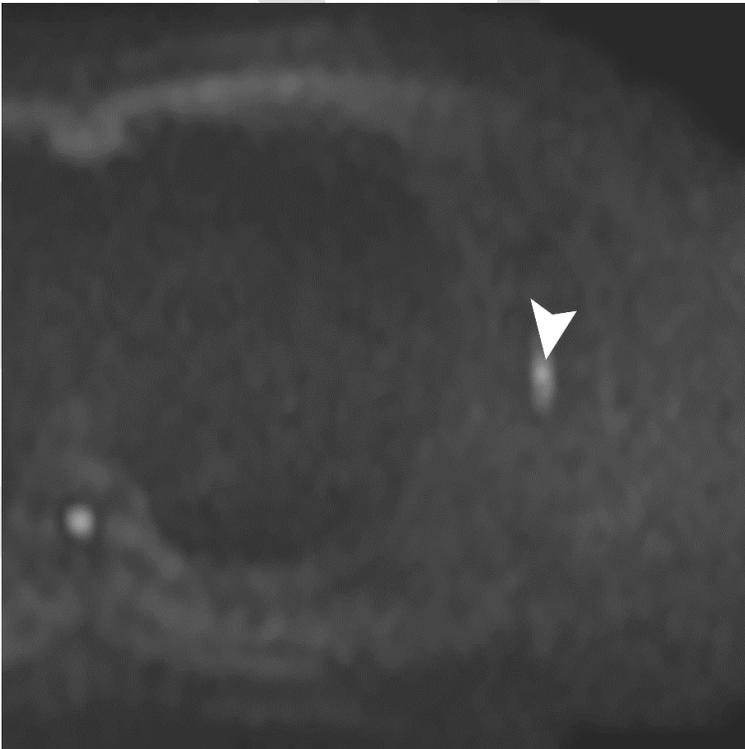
Images in a 53-year-old man 42 days after COVID-19 vaccination. (A, B) Axial T2-weighted image (A) and diffusion-weighted image (DWI) (B) obtained at post-vaccination MRI demonstrate an enlarged lymph node (arrows) in the left axilla ipsilateral to the vaccinated site. (C, D) Axial T2-weighted image (C) and DWI (D) obtained at pre-vaccination MRI demonstrate the corresponding lymph node (arrowheads). The enlarged lymph node on post-vaccination MRI scans is larger than the corresponding lymph node on pre-vaccination MRI scans. In this participant, the enlarged lymph node on the T2-weighted image at post-vaccination MRI demonstrates iso-intensity to the corresponding lymph node on T2-weighted image at pre-vaccination MRI.
